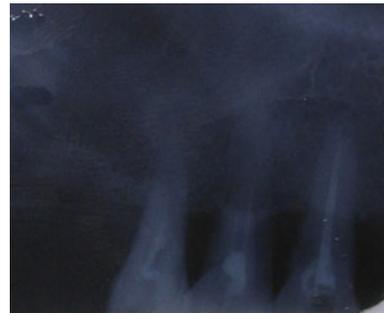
Pre-op IOPA radiograph of retained teeth for telescopic copings
